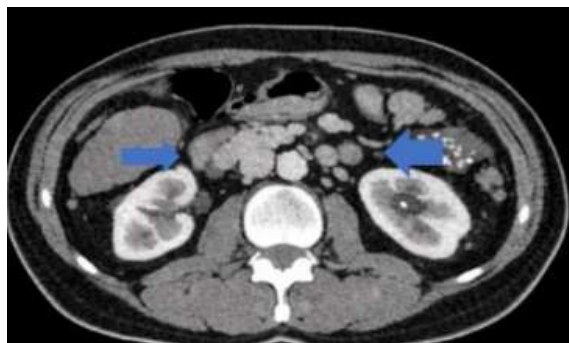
Adrenal computed tomography performed at Hassan II University Hospital in Fez showing enlargement of the left adrenal gland consistent with hyperplasia, along with atrophy and micronodular changes of the right adrenal gland.
